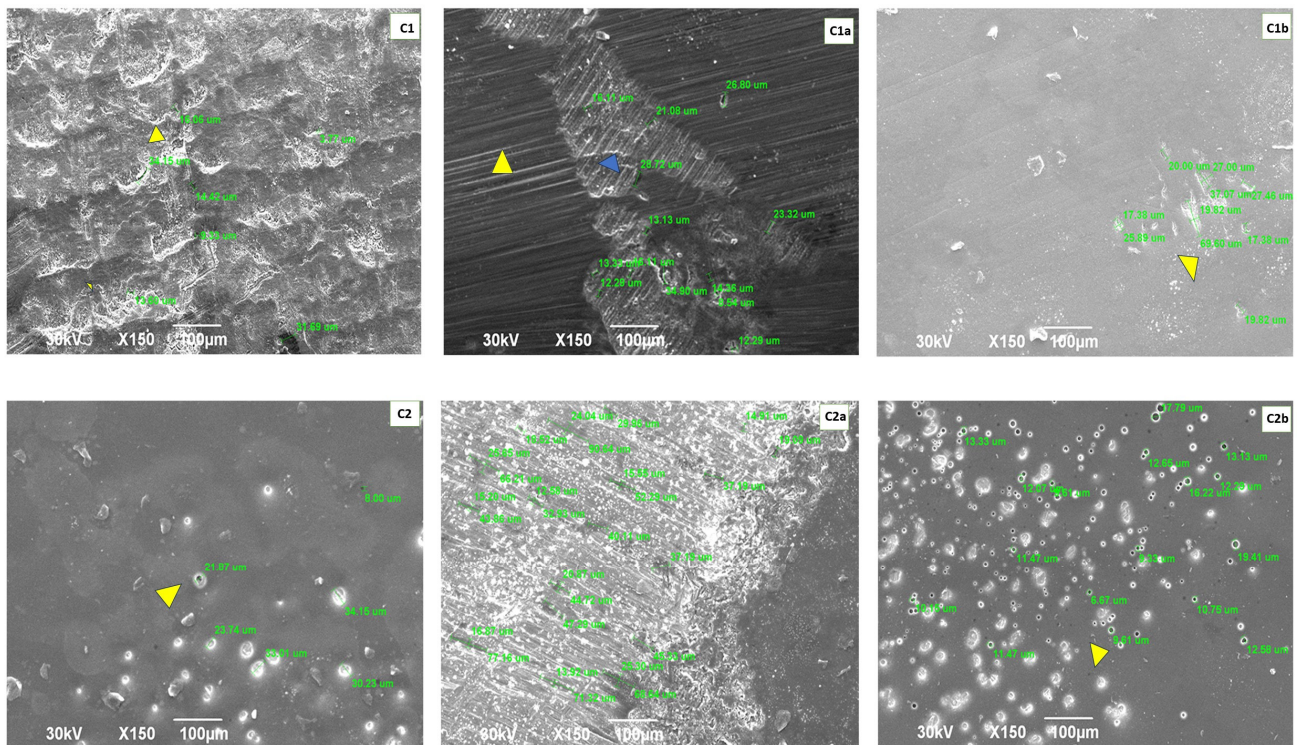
Representative SEM images of the CAD/CAM milled zirconia samples: C1—zirconia milled and polished samples; C1a—zirconia milled and polished samples treated with ultrasonic scaling; C1b—zirconia milled, polished and brushed samples; C2—zirconia milled and glazed samples; C2a—zirconia milled and glazed samples treated with ultrasonic scaling and C2b—zirconia milled, glazed and brushed samples.
